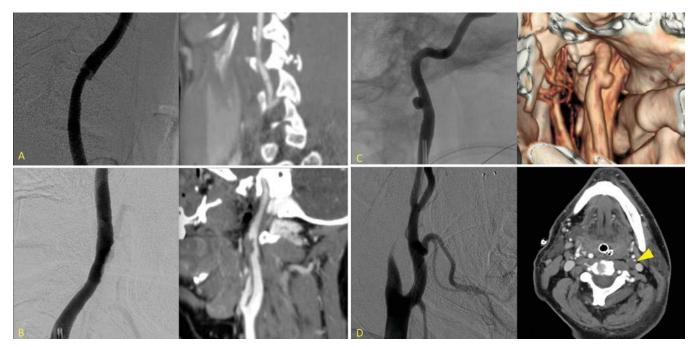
Examples of Biffl Grade I–IV injuries; DSA (left) and CTA (right). Type I VA injury (A), Type II internal carotid artery (ICA) injury (B), Type III ICA injury (C), and Type IV ICA injury (D). Figure is available in color online only.
